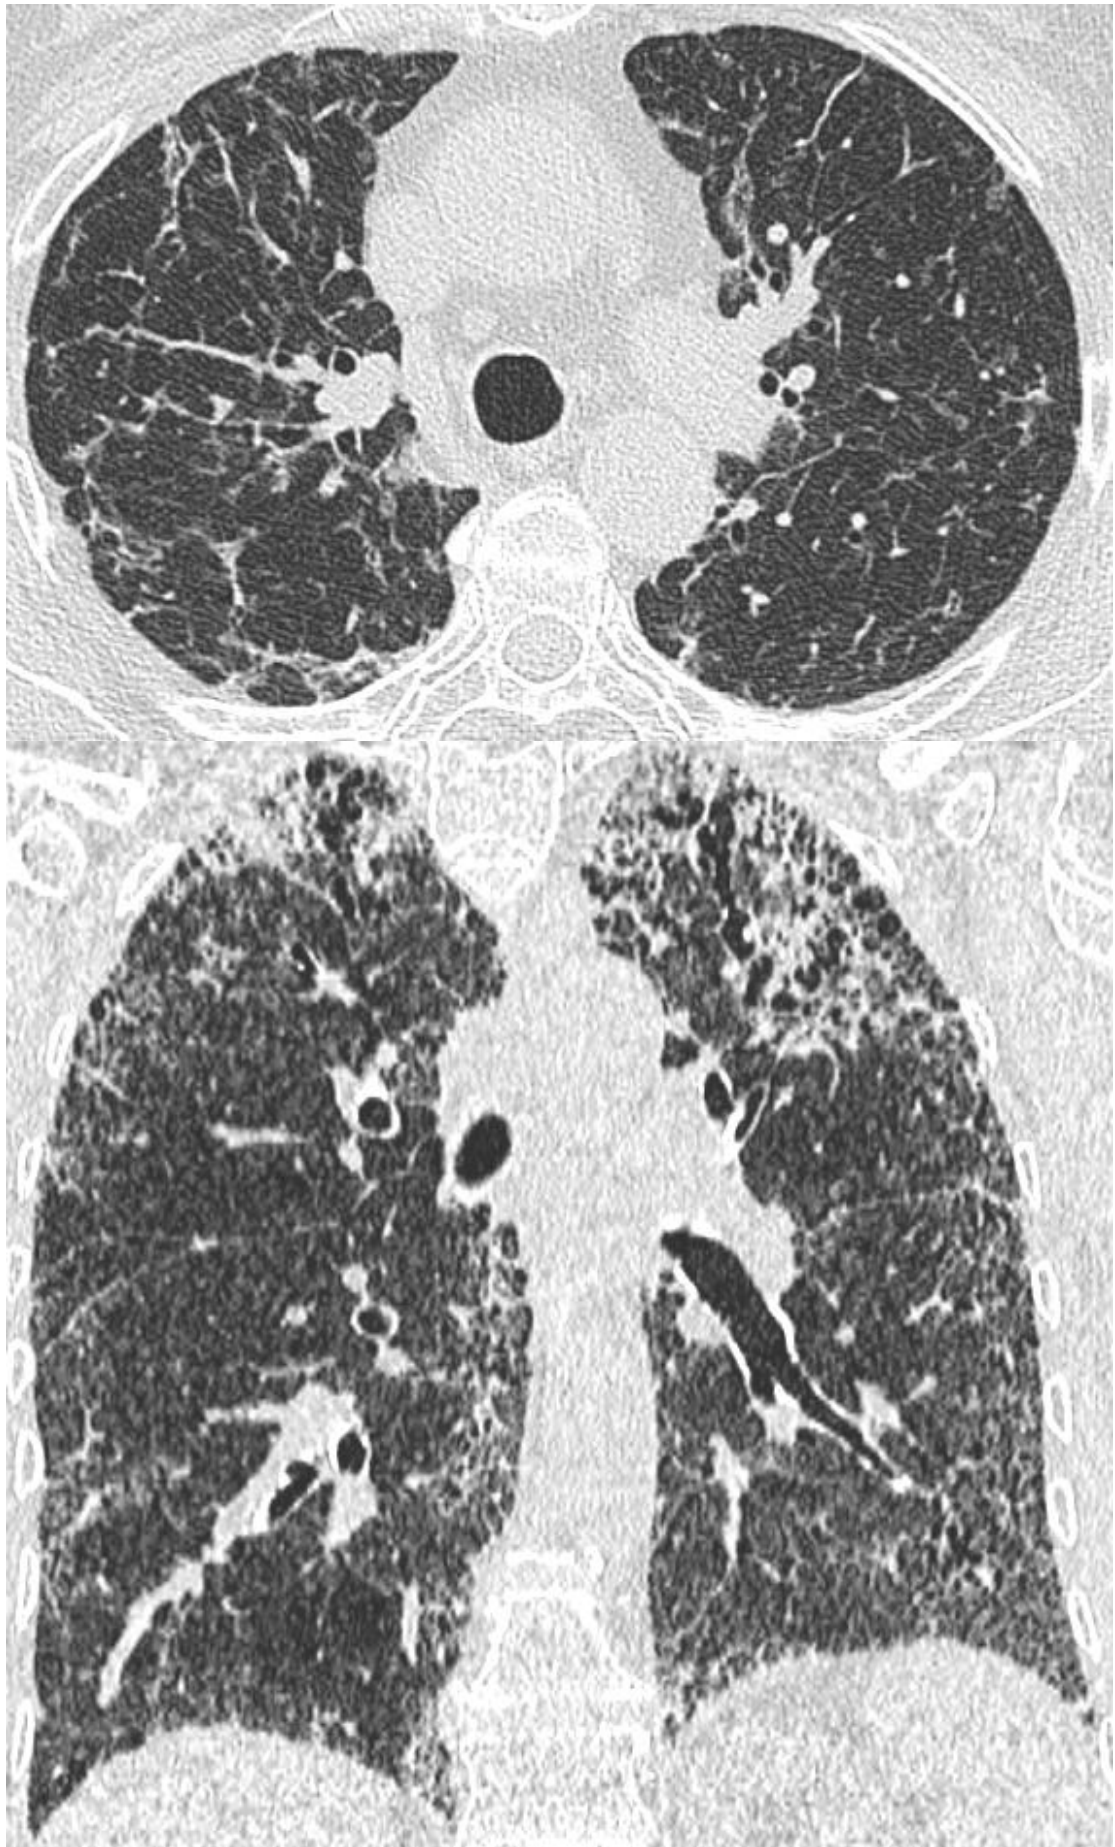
CT imaging for two patients who were found to be inconsistent for a UIP pattern on CT. Patient A (Axial image), a 77-year-old never smoker demonstrated peribronchovascular and perilobular consolidation in keeping with an organizing pneumonia pattern, but did not fulfill criteria for undifferentiated connective tissue disease. Patient B (Coronal image) a 79-year-old never smoker, demonstrated an upper lobe predominant pattern of fibrosis but had no associated CT or clinical features of hypersensitivity pneumonitis and was given a differential diagnosis of idiopathic pulmonary fibrosis/chronic hypersensitivity pneumonitis.
